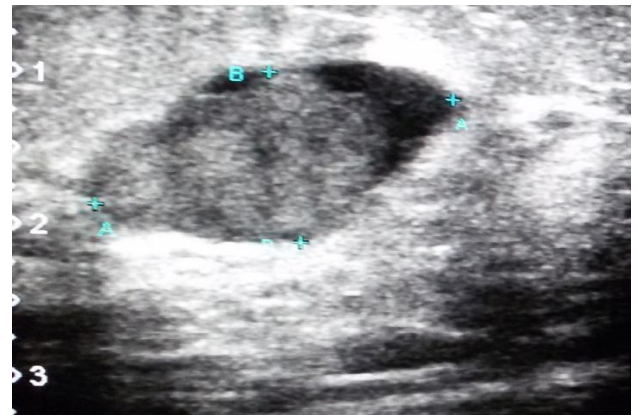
Ultrasound examination of right breast - an oval shaped lesion with central solid component.
